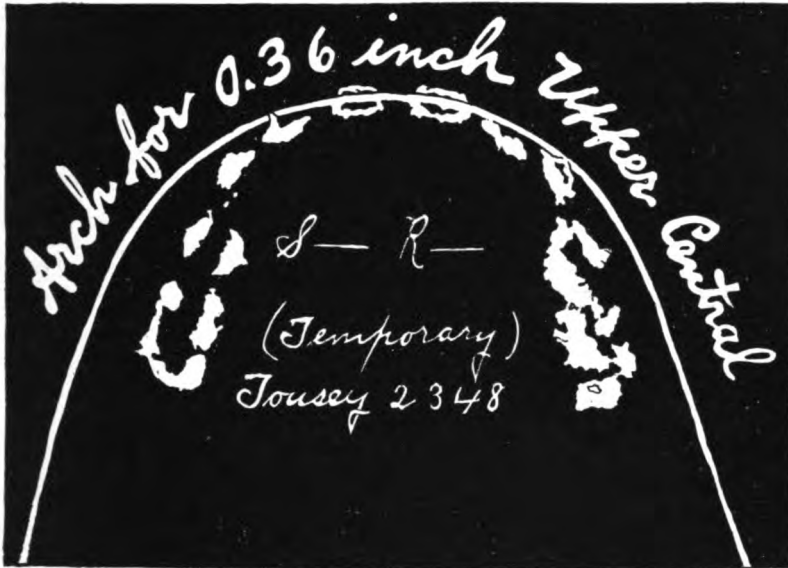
Narrow curve formed by the temporary teeth in a case in which the permanent teeth were shown by the x-ray to require a broad curve.
